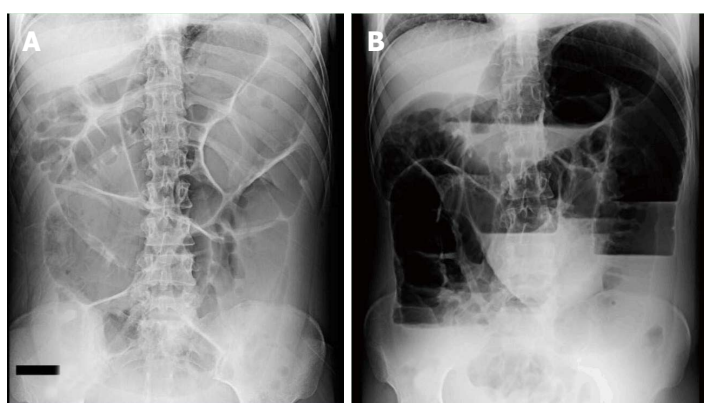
Plain abdominal radiograph revealing diffuse dilatation of the small bowel and air-fluid levels. A: Supine view; B: Upright view.
